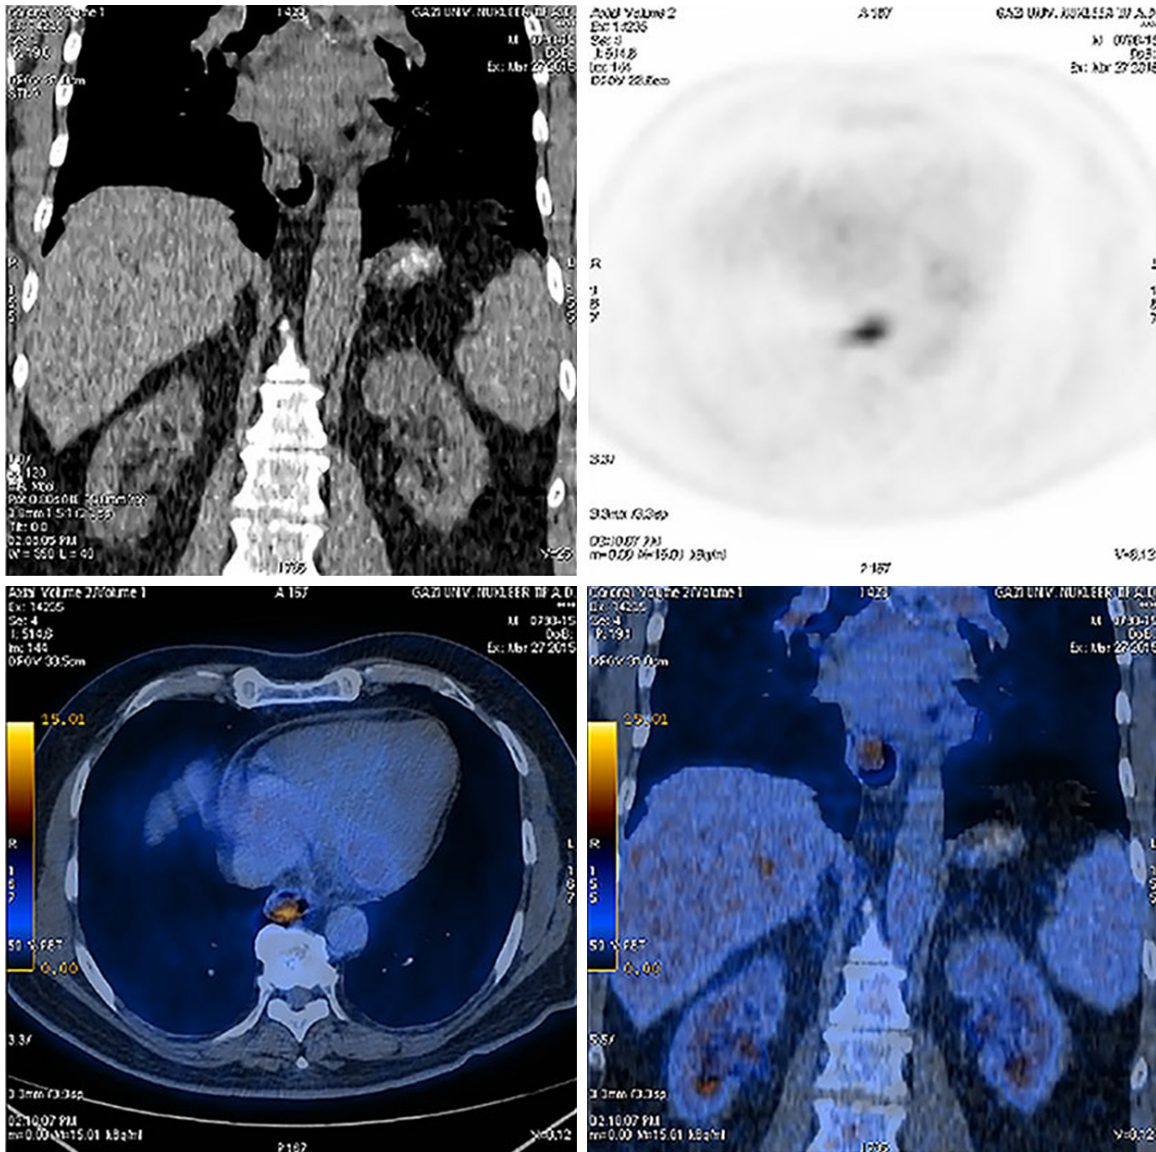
FDG PET image of the increased uptake by primary malignant melanoma of the esophagus.
